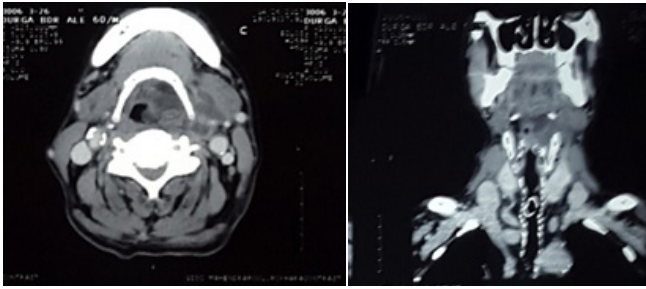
CT Scan showing ill defined collection in paraglottic space and its extension outside larynx
